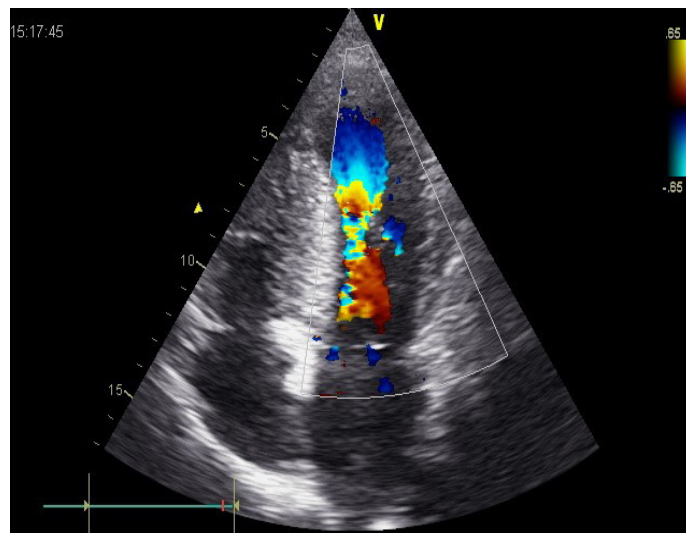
Apical four chamber view, Color flow Doppler imaging showing a very narrow and constricted area at the middle ventricle level in systole.
